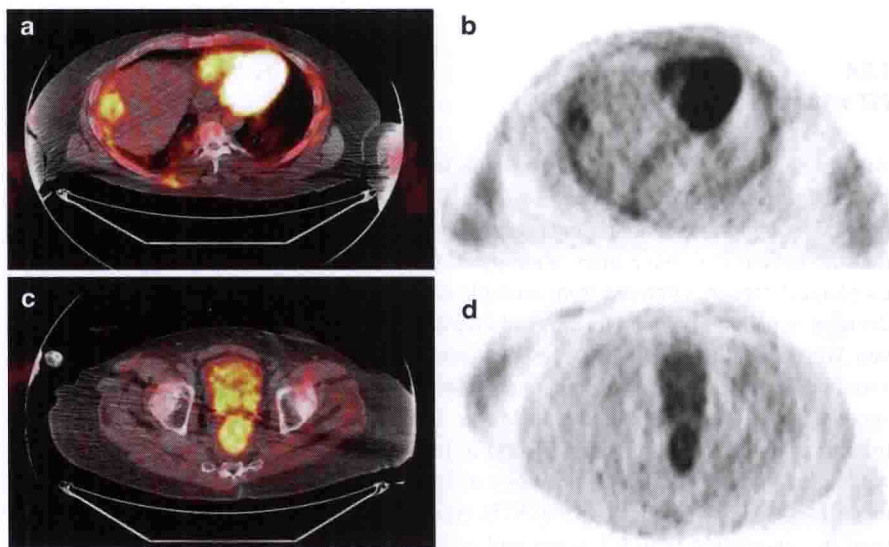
Fused positron emission tomography/computed tomography (PET/CT) scans (a, c) and PET alone (b, d) of a patient with a lesion seen in the rectum (images c, d) and in the liver (images a, b). Because of an elevated creatinine the routine CT scan was done without contrast and did not show this liver lesion, although a larger lesion in the dome was visualized (not shown)
